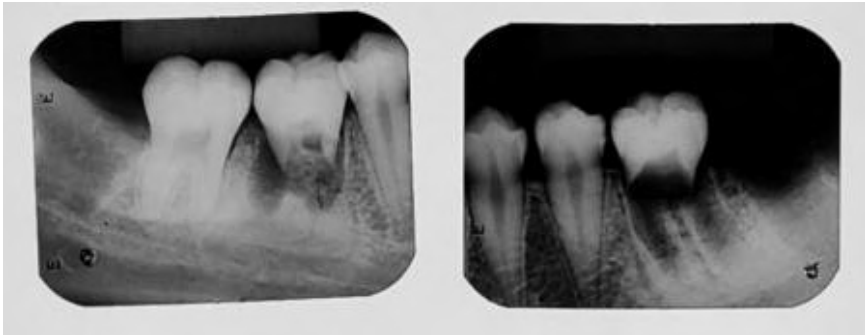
Periapical radiographs after 14 days of auto transplantation.
